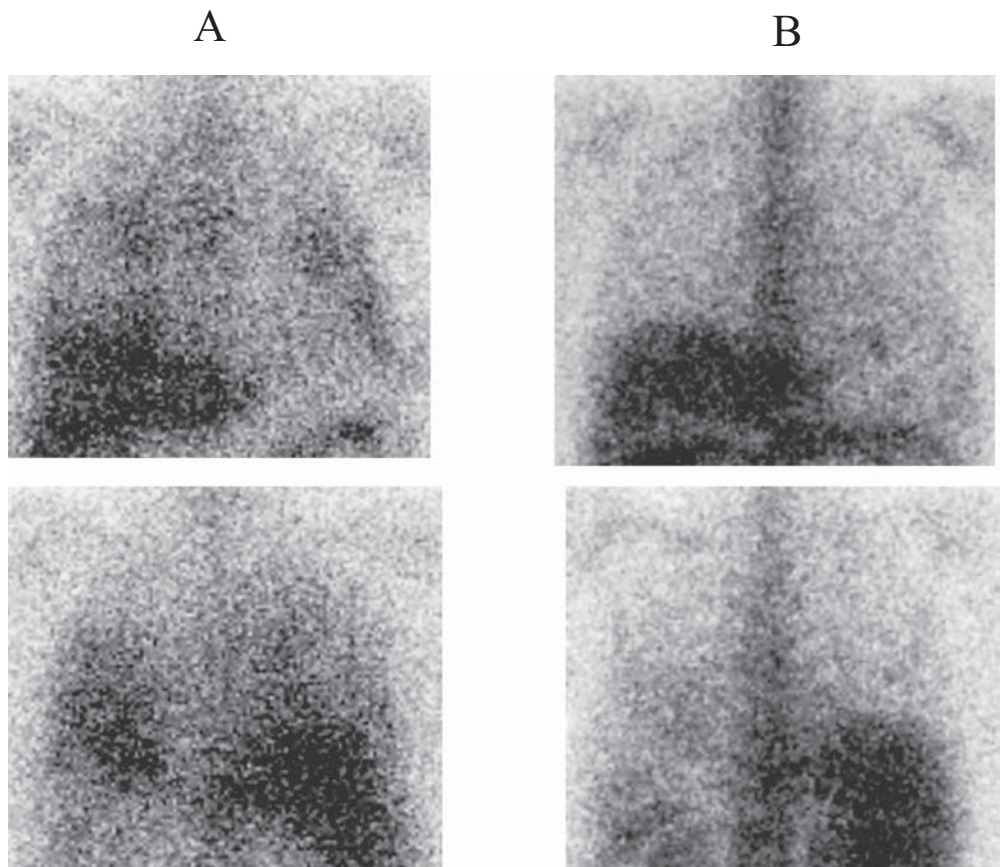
Gallium scintigrams of the chest before and after UT pulse therapy. A On admission; the gallium scintigram revealed marked abnormal isotope accumulation with dorsal predominance in the middle and lower lung zones bilaterally. B After 5 courses of UT pulse therapy; the abnormal isotope accumulation in the lungs had almost disappeared
